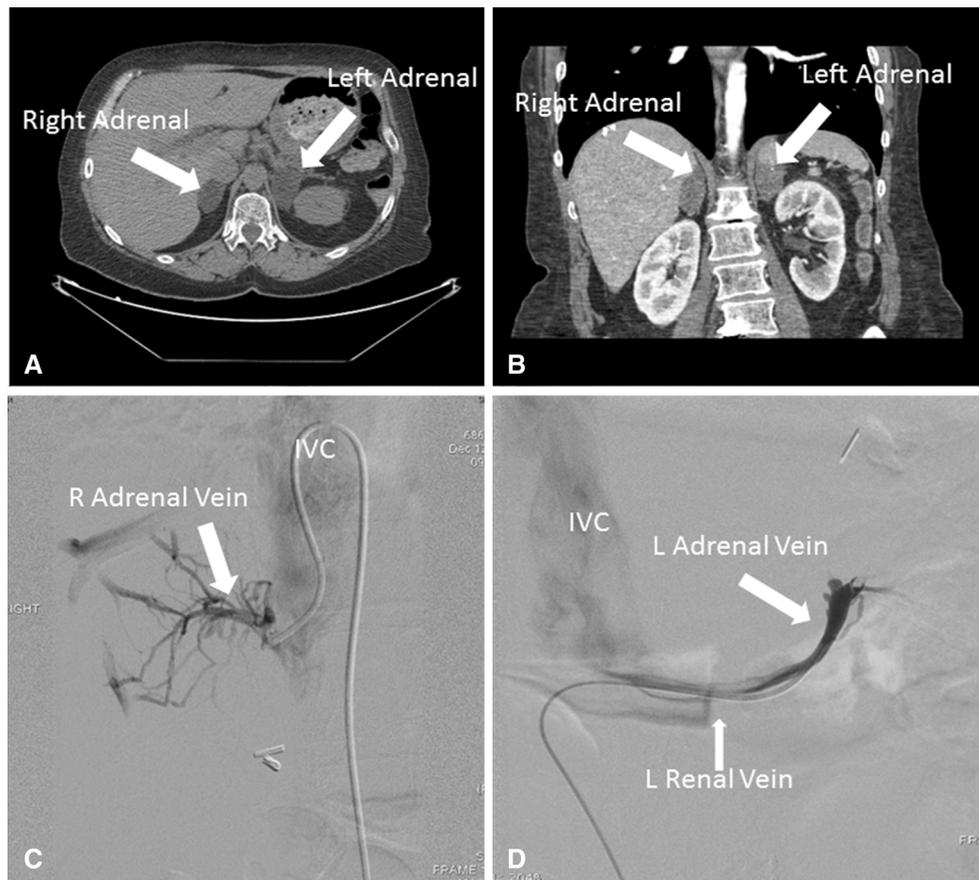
Representative CT and AVS images (case 1). a Axial CT scan image of right and left adrenal glands b Coronal CT scan image of right and left adrenal glands c Right adrenal vein catheterization d Left adrenal vein catheterization
